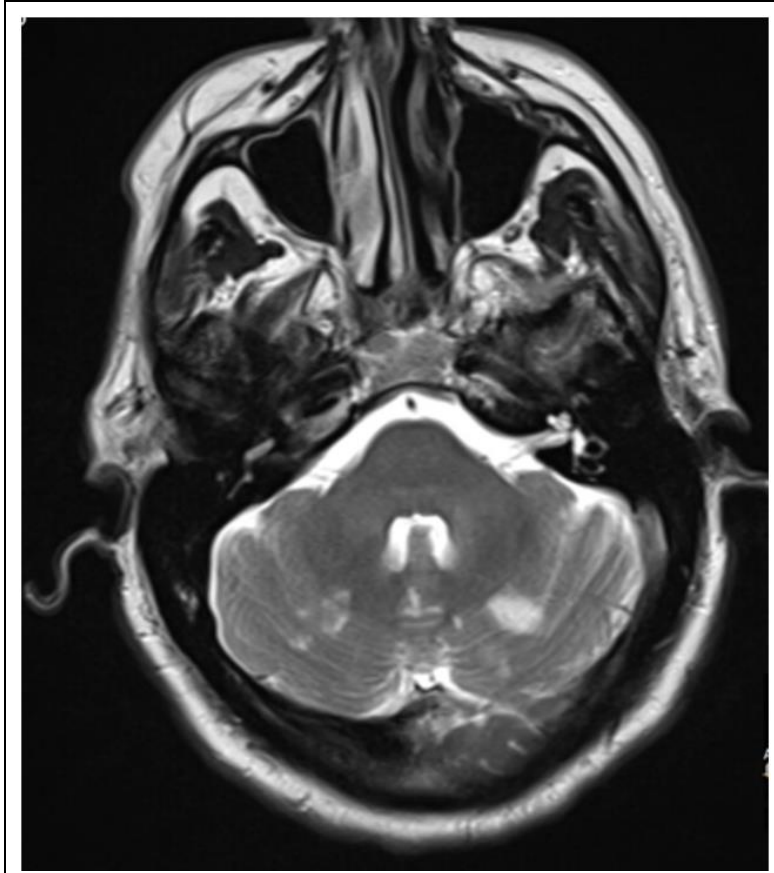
MRI brain showing left cerebellar infarct at initial diagnosis.
